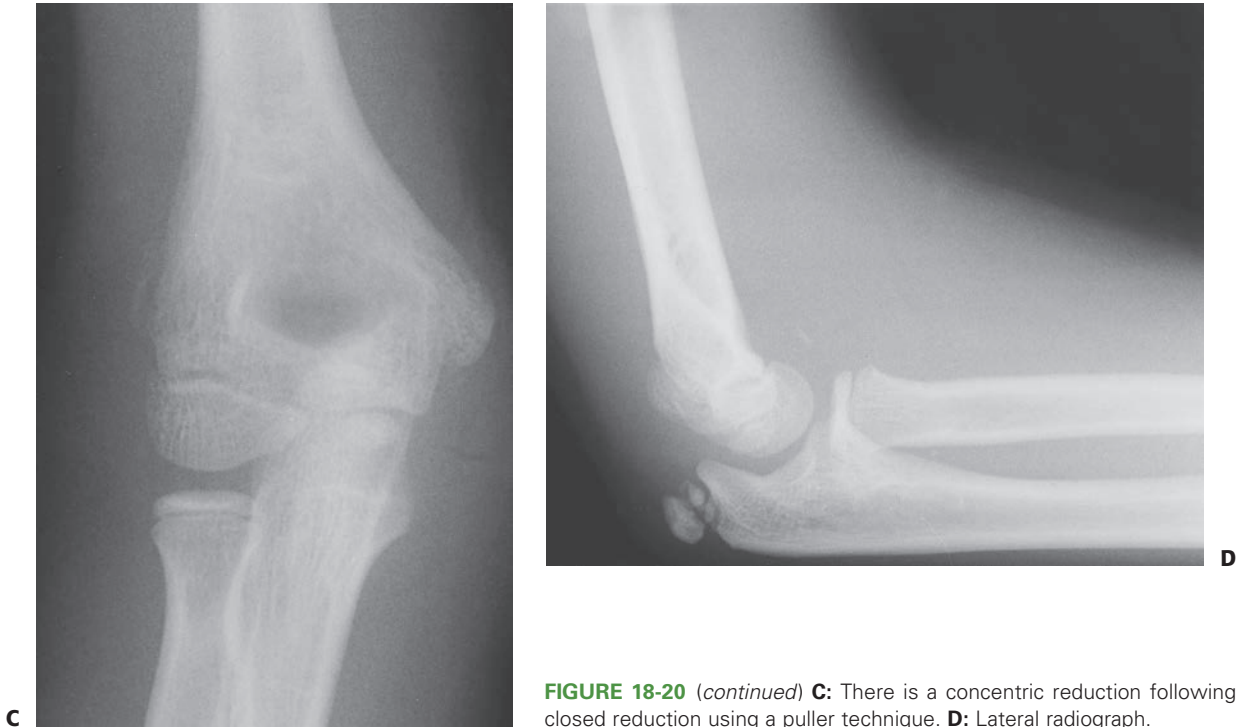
(continued) C: There is a concentric reduction following closed reduction using a puller technique. D: Lateral radiograph.
